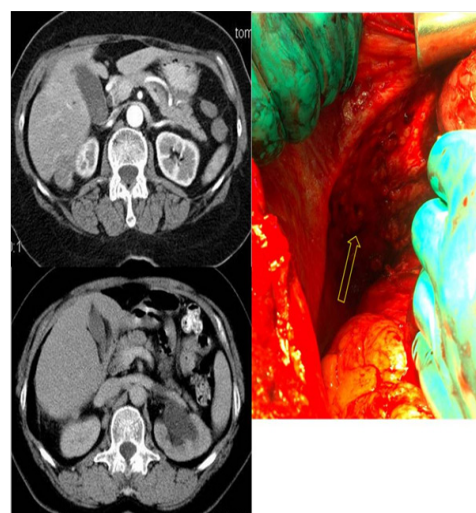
Implants of hepatorenal recess of peritoneum (Morrison pouch) on CT scan and intraoperative image.
